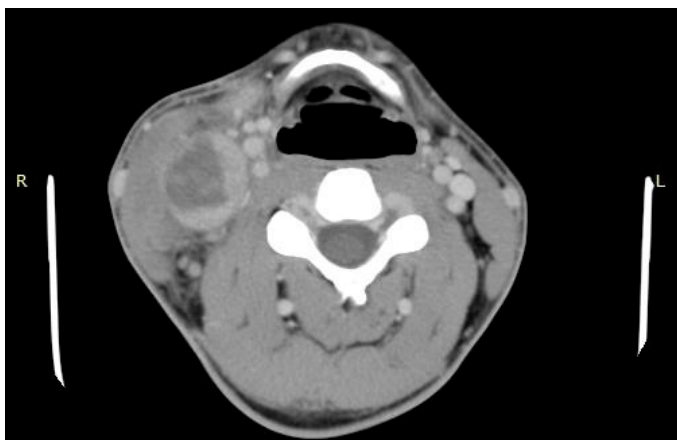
Presentation of the tumor in preoperative contrast-enhanced cervical CT scan.
